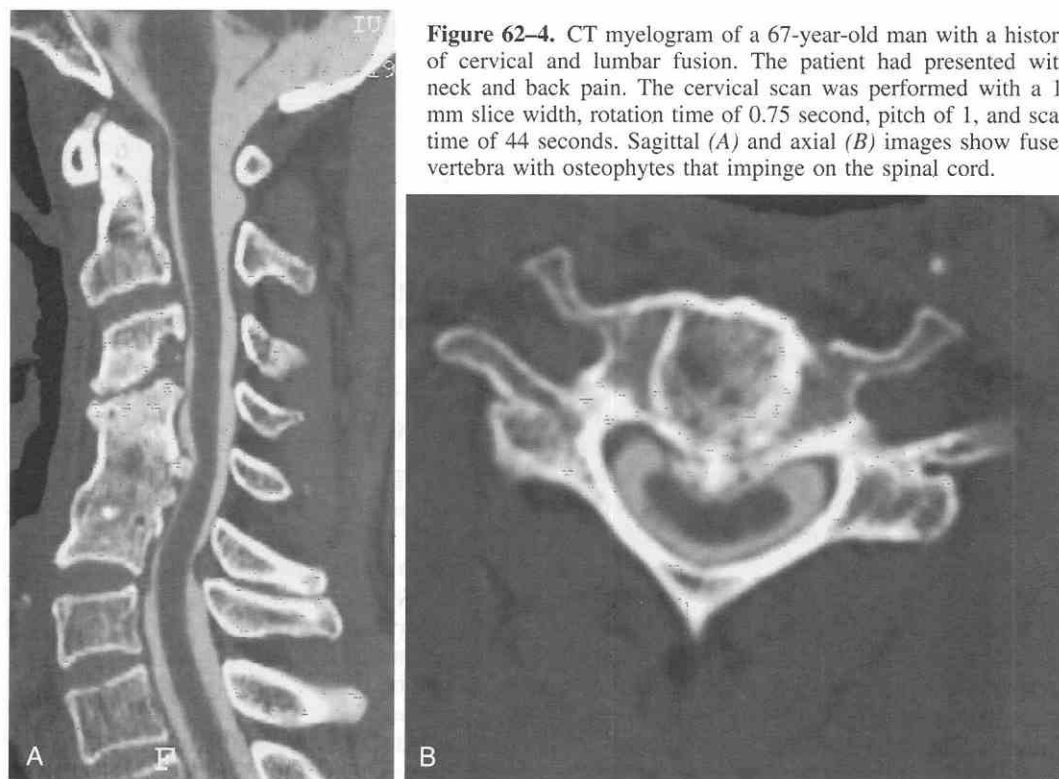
CT myelogram of a 67-year-old man with a history of cervical and lumbar fusion. The patient had presented with neck and back pain. The cervical scan was performed with a 1-mm slice width, rotation time of 0.75 second, pitch of 1, and scan time of 44 seconds. Sagittal (A) and axial (B) images show fused vertebra with osteophytes that impinge on the spinal cord.
